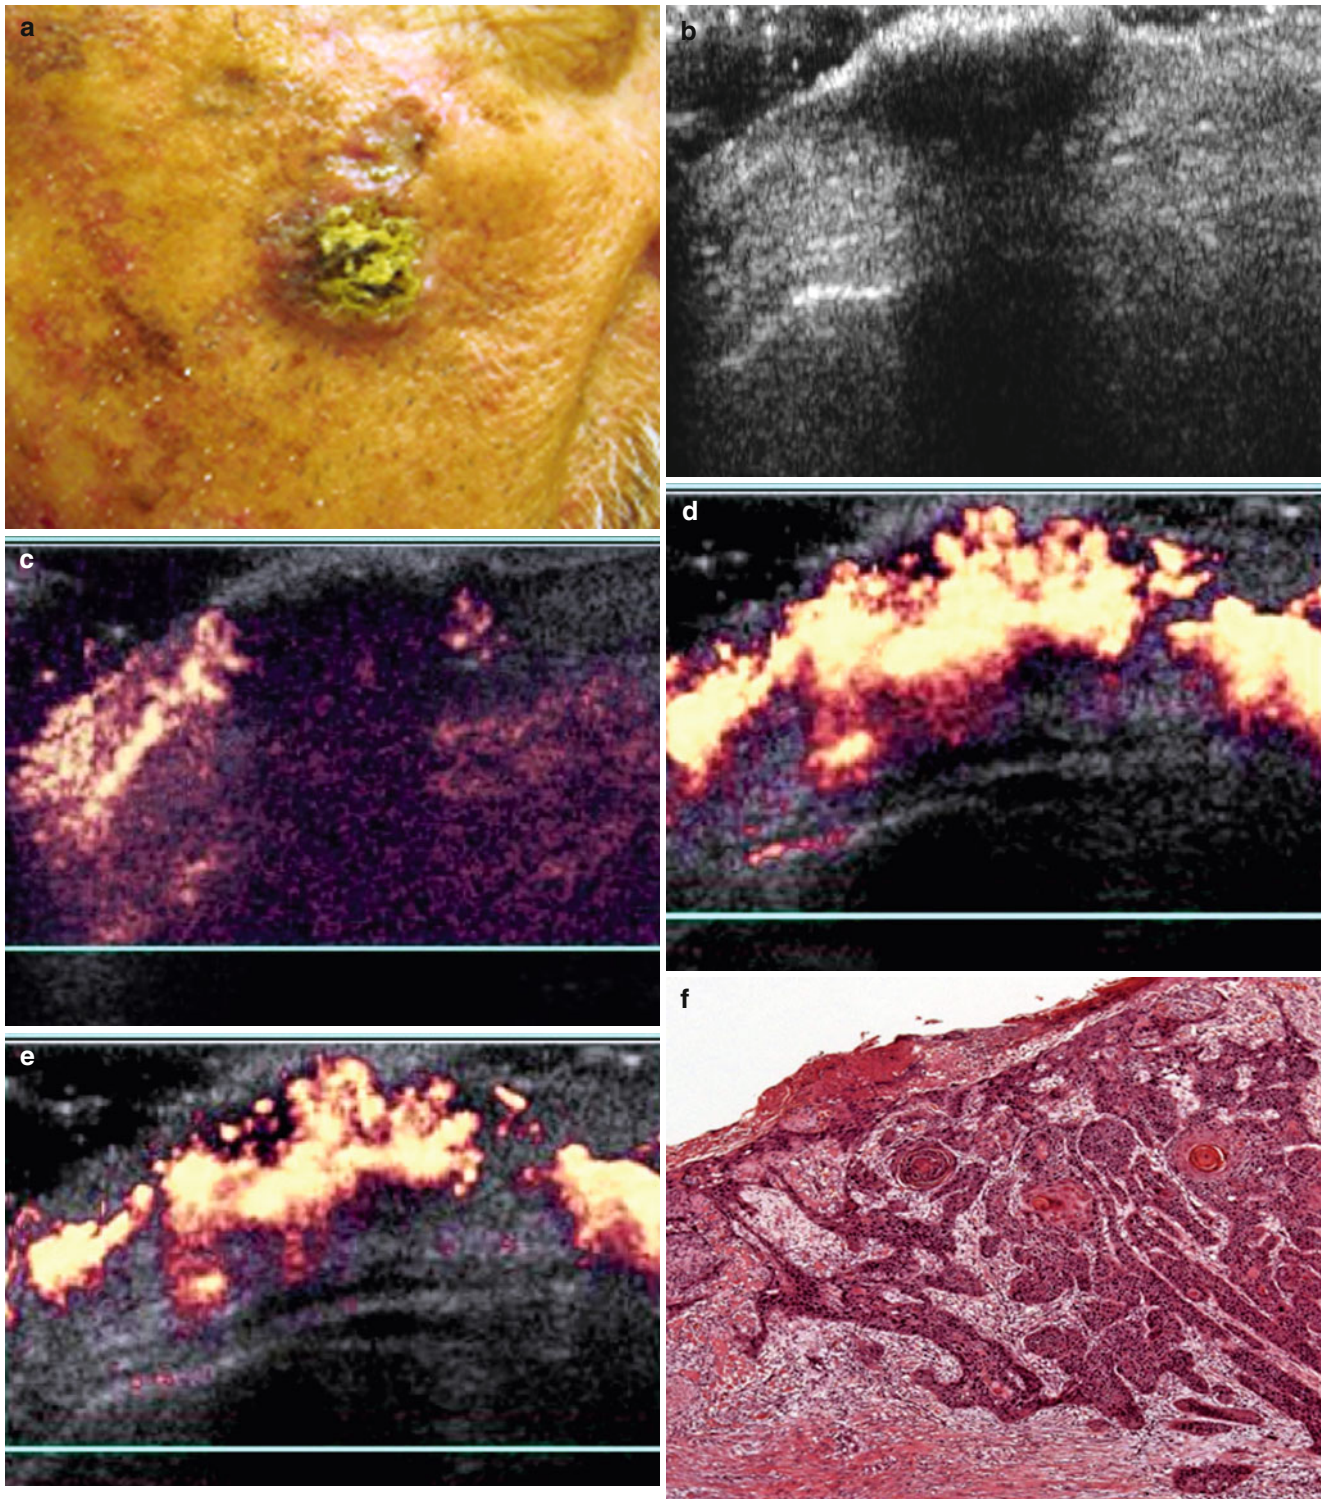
(a) Squamous cell carcinoma in malar region. (b) Grey scale ultrasonography—Lesion partially characterized with attenuation of sound beam caused by hyperkeratosis. (c) Power Doppler ultrasound
